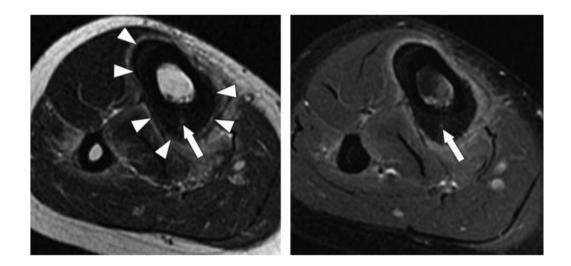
Intracortical hemangioma of the tibia - Axial T2WI/Post contrast T1WI MR images revealing diffuse cortical thickening (arrowheads) with intracortical small lesion (arrow) and adjacent soft-tissue edema(4).
